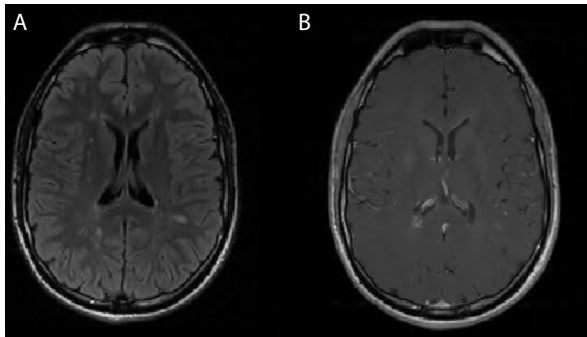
A. Follow-up MRI scan of the brain in T2-weighted FLAIR sequence, axial plane. MS lesions in the brain (hyperintense areas). B. Follow-up MRI scan of the brain in T1-weighted contrast-enhanced sequence, axial plane
